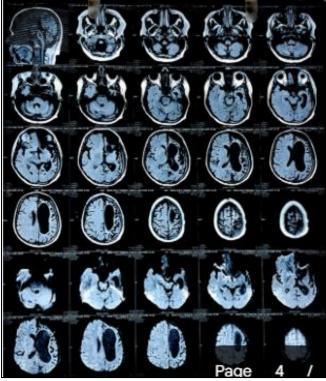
MRI images Showing Cerebral Hemi atrophy, Ventricular Enlargement (Ipsilateral Ventriculomegaly), Hyperpneumatization of the left Frontal Sinus, and Compensatory Skull Changes.
